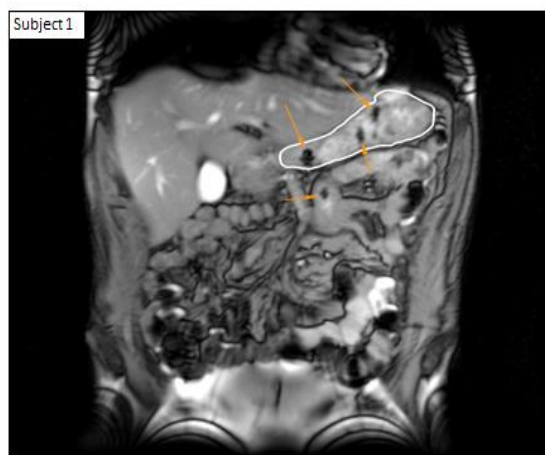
MRI picture showing the localization and disintegration behavior of a matrix tablet taken 4 h after administration of the matrix tablet containing 100 mg of caffeine to a healthy subject 30 min after FDA meal with 240 mL of tap water ($n = 12$).
